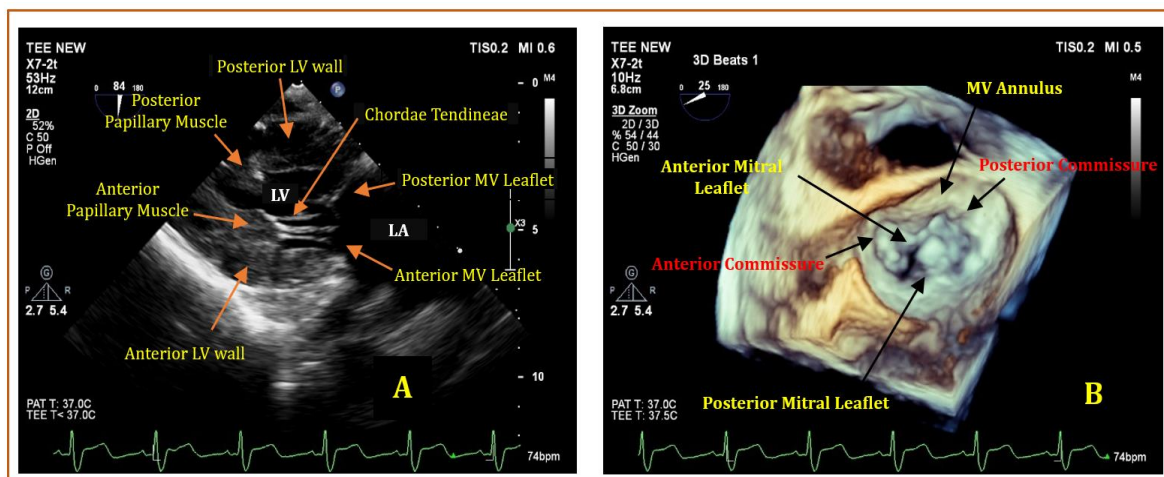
2D & 3D Transesophageal echocardiography to demonstrate components of “Mitral valve apparatus”. Image A) Trans Gastric 2 Chamber View (TG-2CV) obtained at (80-90⁰) showing mitral valve leaflets, chordae tendineae, papillary muscles and supporting left ventricular walls. B) 3D full volume single beat acquisition of mitral valve from LA perspective at midesophageal probe position and multiplane angle at (20-30⁰). Showing saddle shaped non-planer mitral valve annulus, anterior and posterior mitral leaflets, and commissures.
